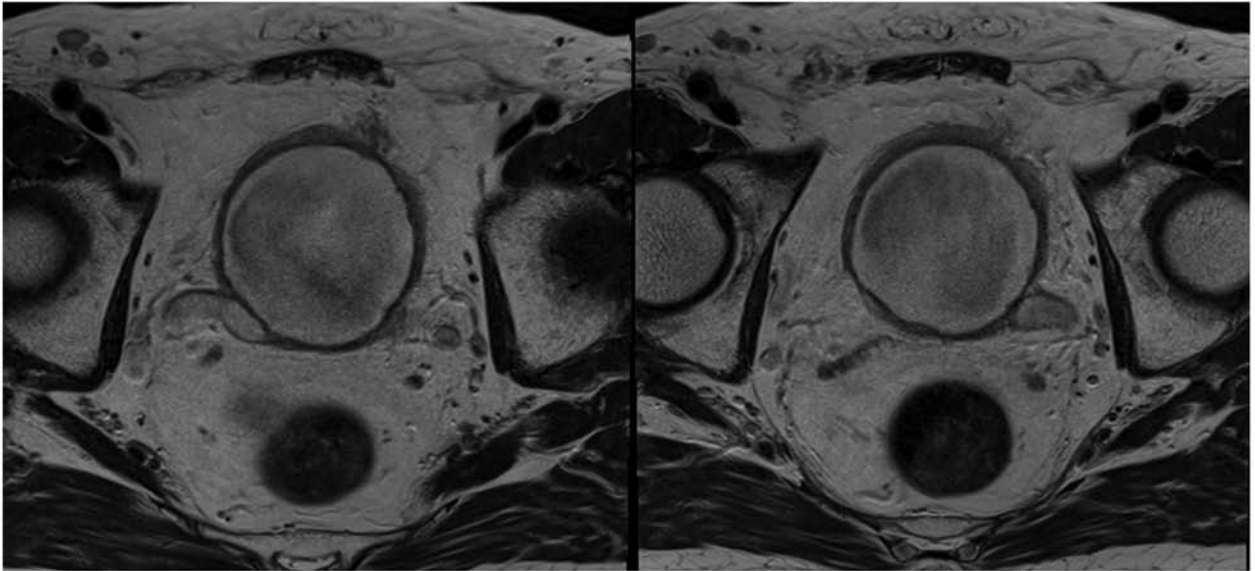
Magnetic resonance imaging shows moderate postvoid residual urine and bilateral distal ureteral dilation.
